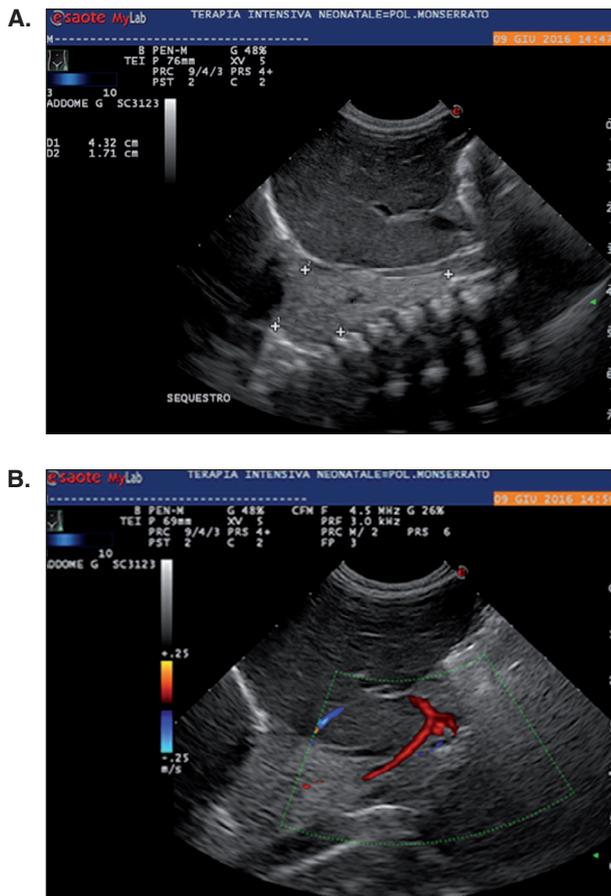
(ABS 62). A. Postnatal US demonstrates the supra-diaphragmatic hyperechoic mass in the right lung. B. Color Doppler sonography identifies an anomalous feeding artery from aorta.
